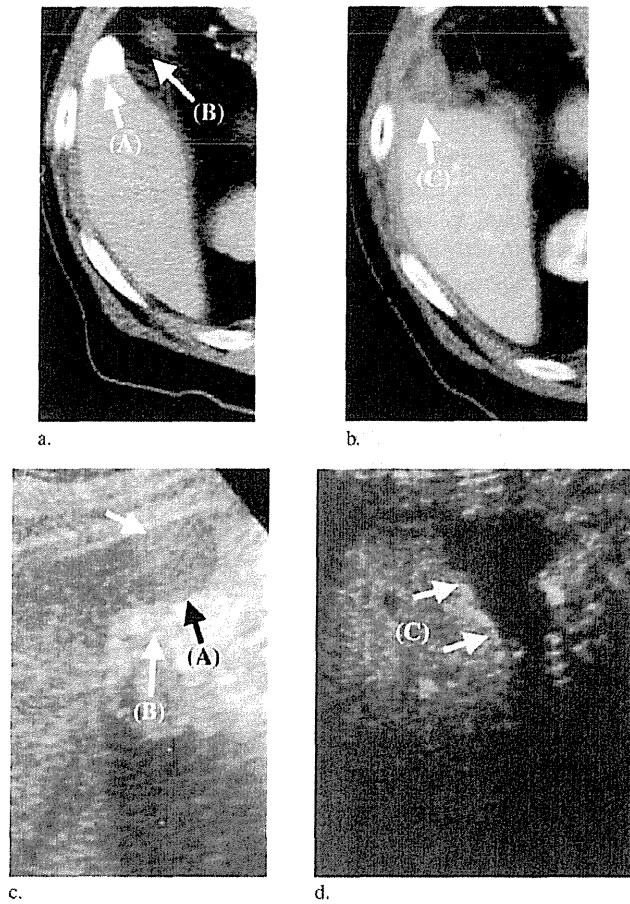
Radiofrequency (RF) ablation of a hepatocellular carcinoma (HCC; *A*) located on the liver surface and adjacent to the intestinal tract (*B*). Computed tomography before (*a*) and after (*b*) RF ablation. The HCC located on the edge of the liver was necrotized completely (*C*). (*c*) Plain ultrasound (US) before RF ablation. (*d*) Contrast-enhanced US after RF ablation shows necrotizing area (*C*).
